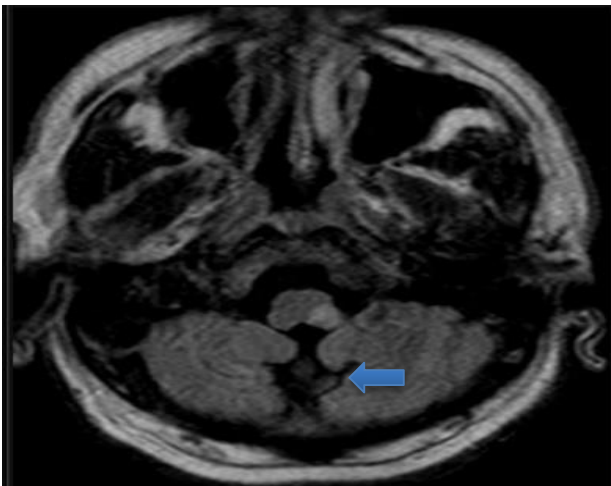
T2 FLAIR image shows hyper-intense foci in left medulla.
